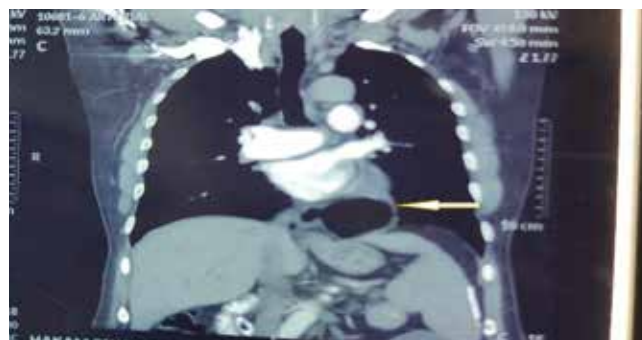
Contrast-enhanced computed tomography (CECT) sagittal section – diverticulum marked with white arrow.
